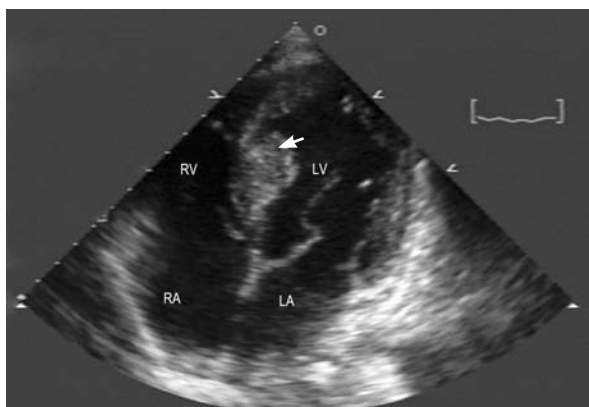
Transthoracic echocardiogram (apical 4-chamber view) shows a mass (arrow) in the inferior basilar interventricular septum.
